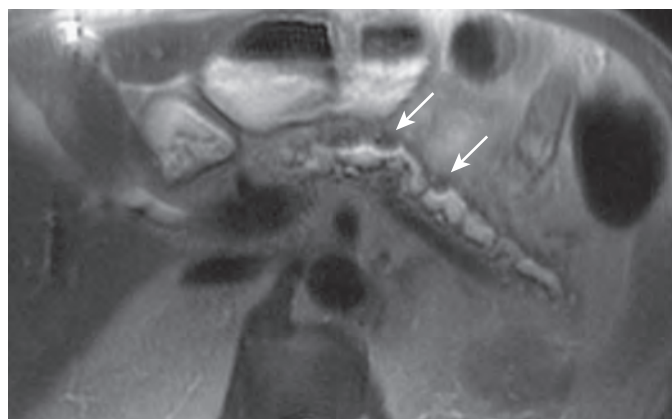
Severe chronic pancreatitis. Axial T2-weighted HASTE MR image shows dilation of the main pancreatic duct and side branches, giving a "chain of lakes" appearance. The pancreas is atrophic and contains signal void areas (arrows) related to calcifications from chronic pancreatitis. (From Miller FH, Keppke AL, Wadhwa A, et al: MRI of pancreatitis and its complications: Part 2, chronic pancreatitis. *AJR Am J Roentgenol* 183:1645–1652, 2004. Reprinted with permission from the American Journal of Roentgenology.)
